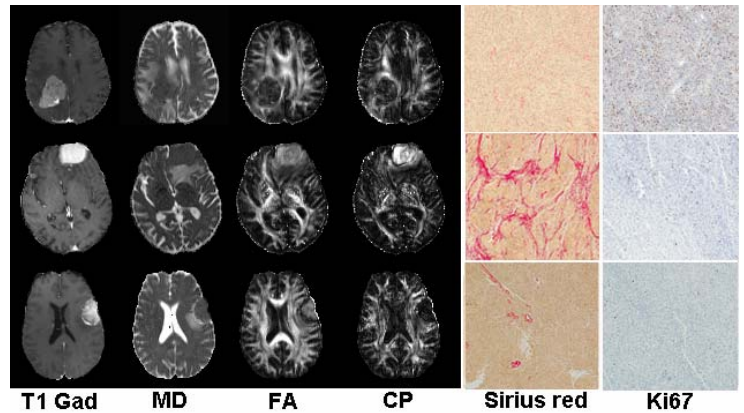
Representative MR images for atypical (upper row), fibroblastic (middle row) and meningothelial (lower row) meningiomas. Fibroblastic meningiomas show high FA, CP and high collagen contents, whereas atypical meningiomas demonstrate high Ki-67.
